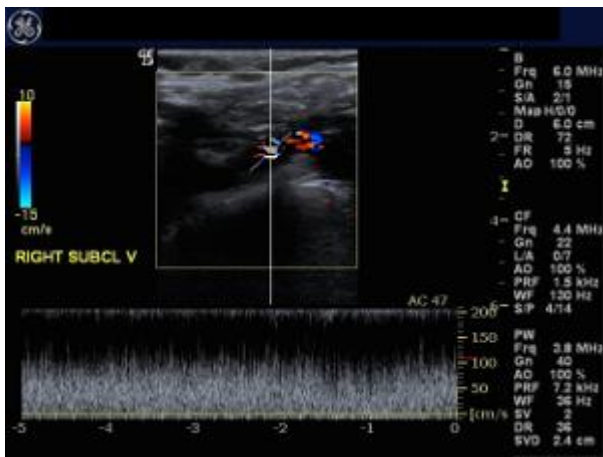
Color and Spectral Doppler image of Proximal Right Subclavian Vein
